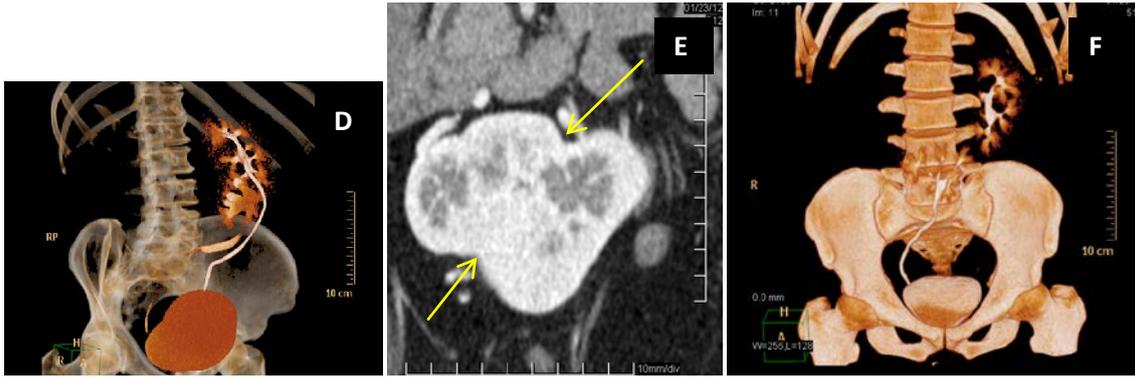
Right-left ERC Fusion (RE lower) 30 year old woman (A and B) of a 43 years (C and D) and a man of 34 years (E and F). (A) Oblique coronal MPR, excretory phase. Note the fusion of the upper pole of the RE with orthotopic kidney lower pole (white arrows). (B) Oblique volumetric CT Reconstruction. Note the independence of the two collecting systems. (C) MPR sagittal oblique excretory phase and (D) volumetric oblique coronal CT. Note the independence of collecting systems. (E) Oblique axial MPR, corticomedullary phase. Note the fusion of the renal parenchyma (yellow arrows). (F) Coronal volumetric reconstruction of TC. Shows the full right collecting system and left collecting system, it is observed that the ureter side, but there was a separate drainage.
